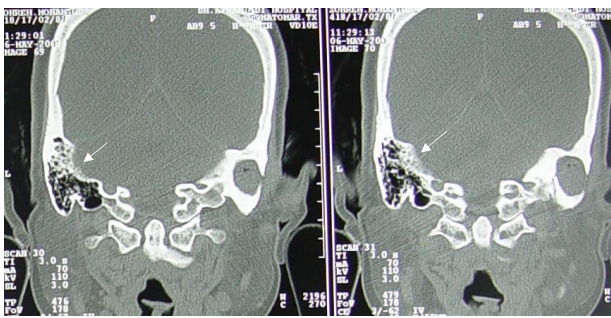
Computed Tomography Displaying a Soft-Tissue Density in the Right Middle Ear Cavity Extending into the Mastoid Cavity and Towards the Cutaneous Postauricular Area
